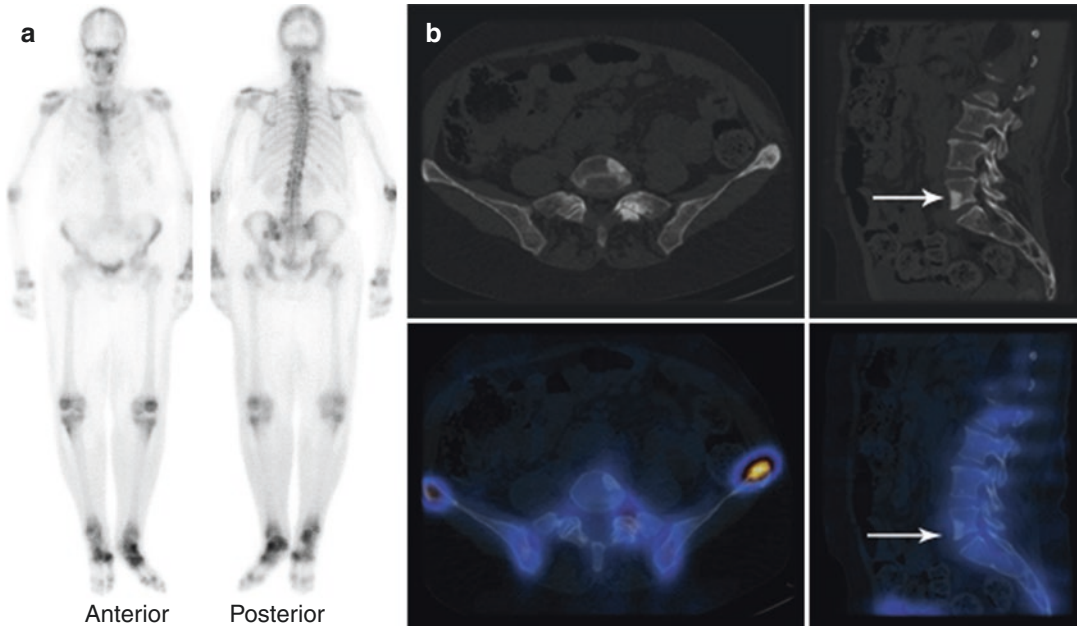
(a, b) Whole-body bone scan (a) of a patient referred for metastatic evaluation shows increased tracer uptake in the knees, ankles and feet suggestive of degenerative changes. On planar imaging, no abnormal tracer uptake is seen anywhere in the skeleton to suggest metastasis. However, SPECT-CT of the pelvis (b) demonstrates mild tracer uptake in the left iliac bone showing two lytic lesions (arrows) suggestive of metastatic disease
